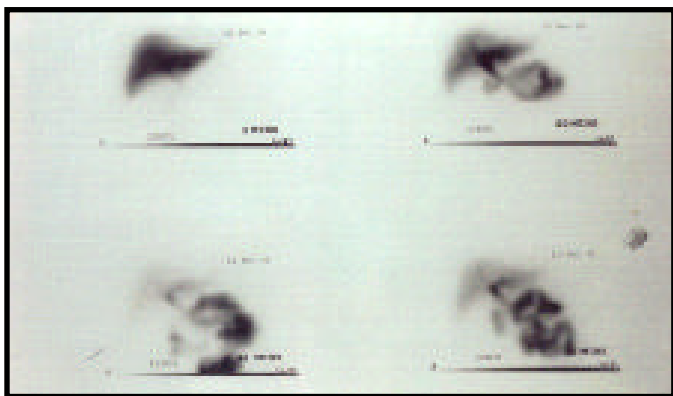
Cholescintigraphy images at 5, 20, 40, and 60 minutes. The gallbladder was not seen in all images and almost all the tracer is in the bowel.
